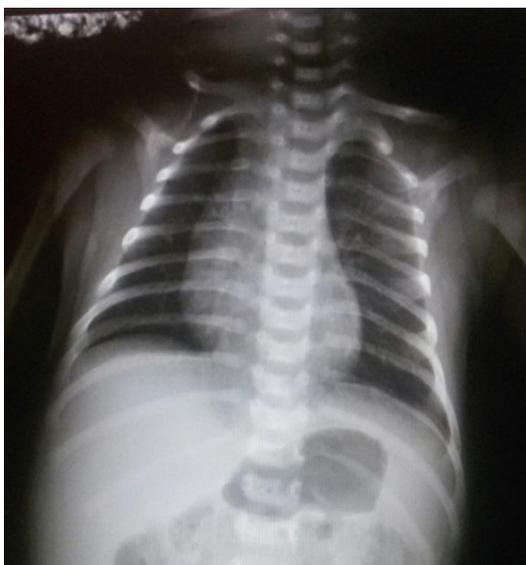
Chest radiograph of the newborn obtained on 15 April 2020, showing no abnormalities in the lung and heart
